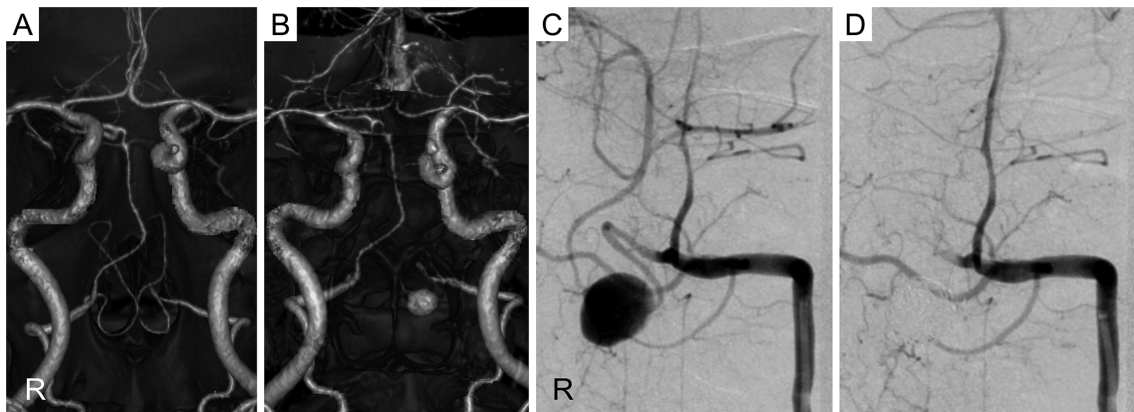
CTA reconstruction showing both PICAs without associated aneurysms (A). CTA reconstruction conducted 1 month after the previous CTA showing a left PICA de-novo aneurysm with associated vasospasm (B). Catheter angiography via the transradial route showing a left PICA aneurysm (C) and complete coil embolization (D).
